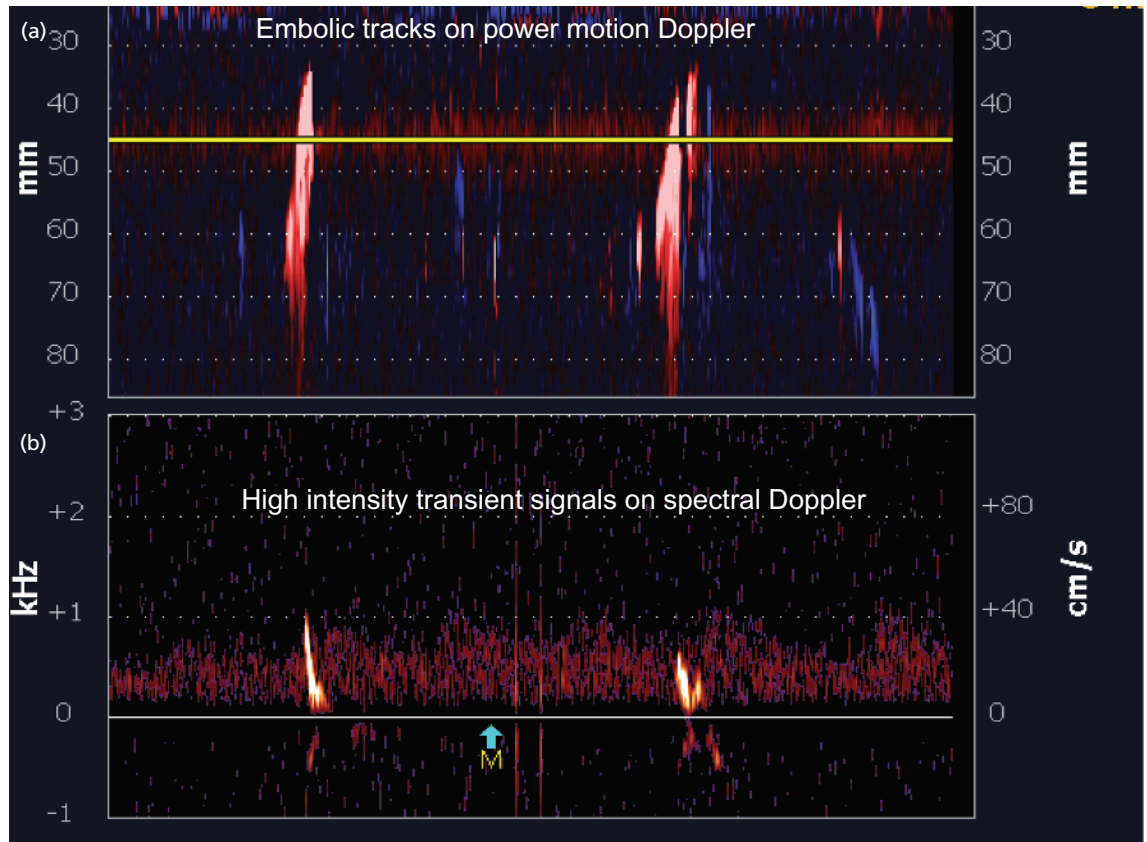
Embolic signals on power motion Doppler TCD. (a) The power motion display tracks emboli as they travel along cerebral vessels in real time (note the incline of tracks from right to left because the horizontal axis represents time and vertical axis represents the depth of vessel location in mm). (b) A spectral Doppler display of emboli at a single depth of insonation (the yellow line across motion display above).
